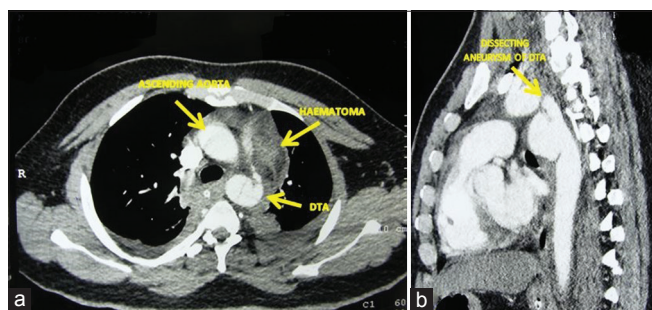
Computed tomography scan (a) transverse section and (b) coronal section showing dissecting aneurysm of the descending thoracic aorta and the adjacent hematoma
